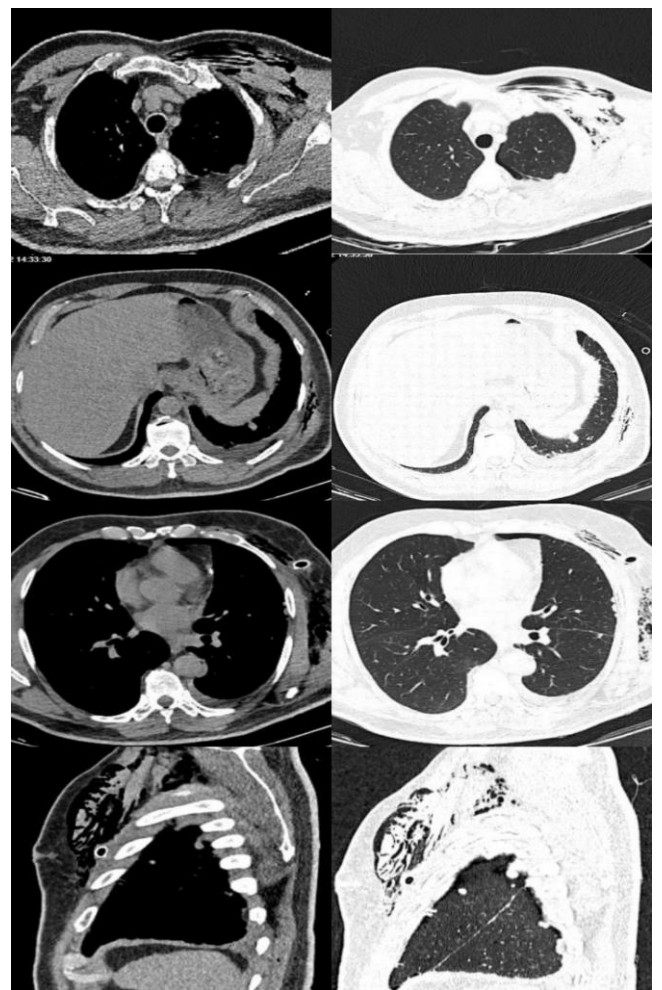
Thorax CT sections, showing pleural nodulation, pleural effusion, pneumothorax and subcutaneous emphysema in the left hemithorax
